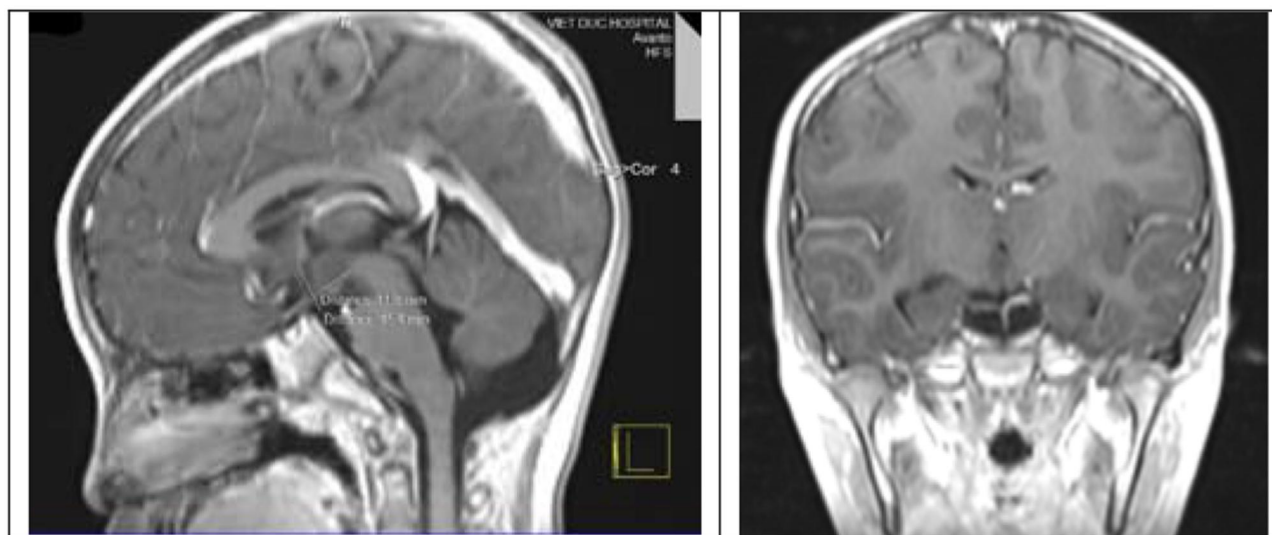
Brain MRI 1.5 Tesla (in hypothalamus area, mainly on coronal and sagittal sequences) revealed a hypothalamus lesion measuring 12*14*8 mm located on the right of the third ventricle, attached to mammillary nuclear and between tuber cinereum and optic chiasma.
